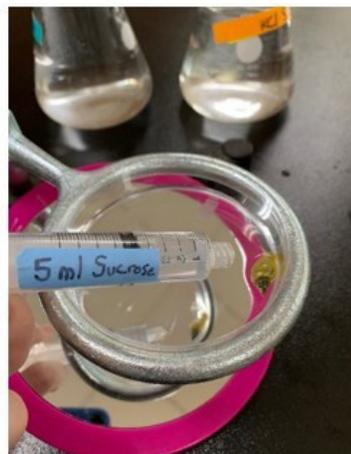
CTA used for all experiments. The conditioned taste aversion procedure (first step). The snail was given 5 mL of a 0.5% sucrose solution (conditional stimulus; shown) followed by 5 mL of a 0.5% KCl solution (unconditional stimulus; not shown). If snails demonstrated good learning, they would avoid biting the sucrose. However, if the snails were poor learners, they would not show any aversion to the sucrose.
